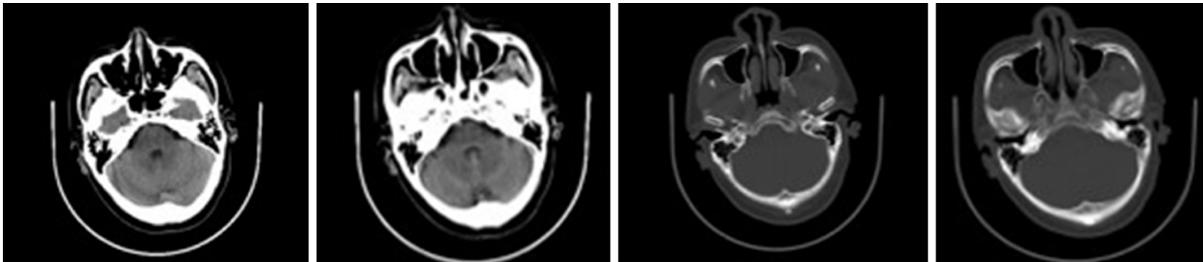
Physical examination (May 26, 2017). An axial head computed tomography scan showed no abnormalities in the nasal cavity or sinuses.
